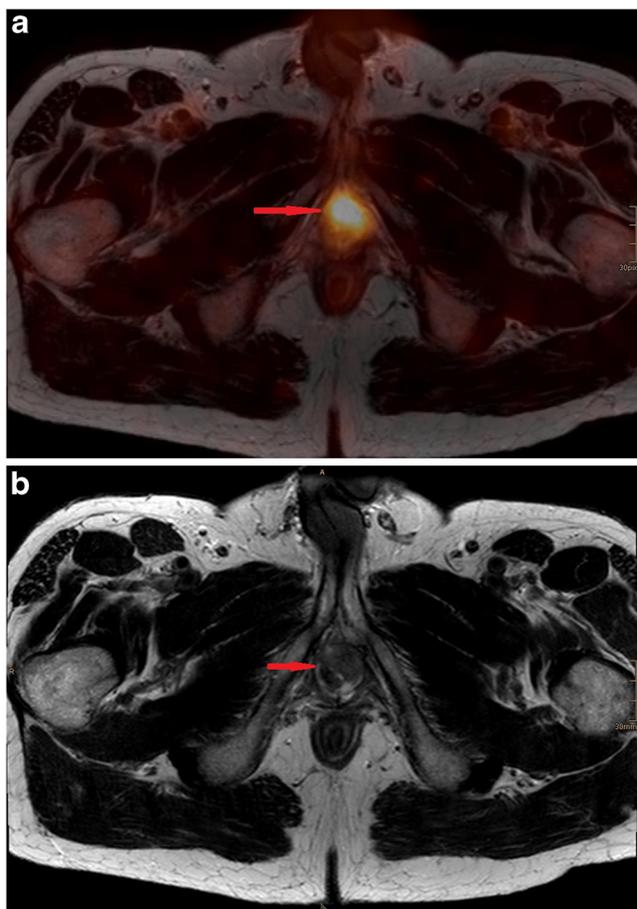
a Axial PET/MRI fusion image demonstrating a lesion with intense FDG uptake in the penile root. b Axial T2-weighted MRI image demonstrating an inhomogeneous lesion in the penile root
